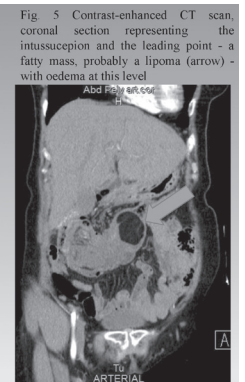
Contrast-enhanced CT scan, coronal section representing the intussusception and the leading point - a fatty mass, probably a lipoma (arrow) - with oedema at this level
